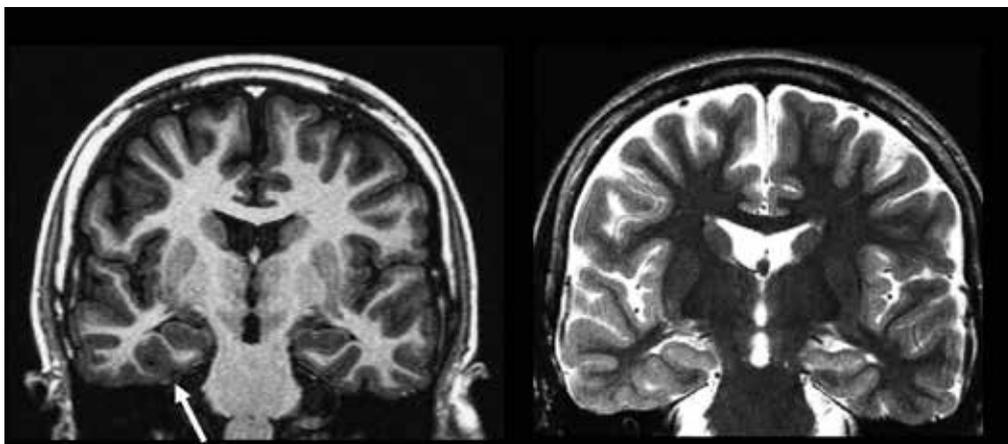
Patient with MTL and previous MRI reported as normal showing right temporal lobe lesion that was low grade ganglioglioma.
